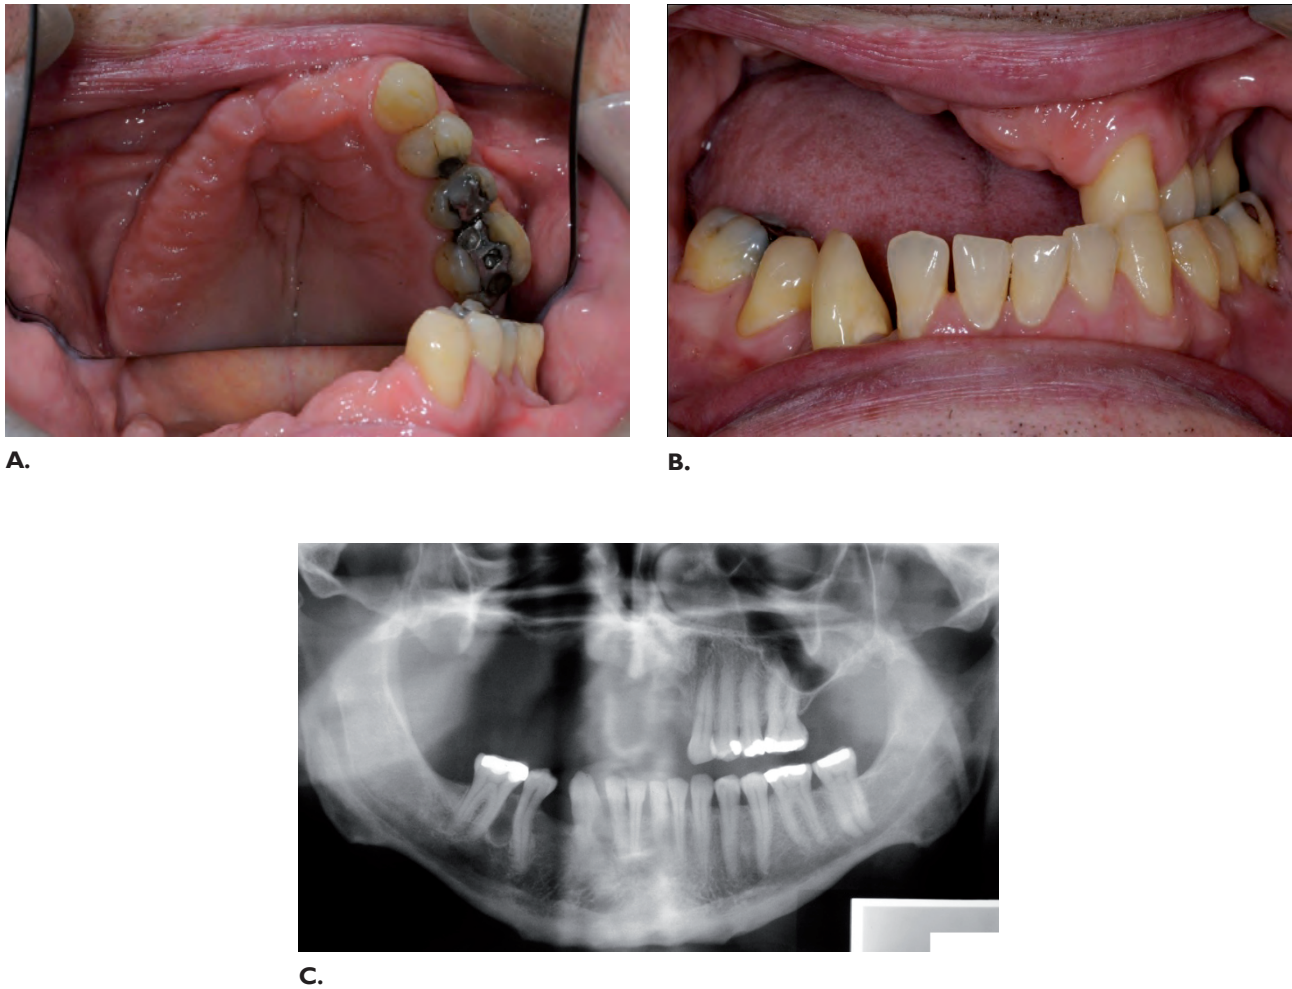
a) and b) Intraoral views showing pattern of tooth loss and associated loss of alveolar height and reduced sulcus depth. c) Radiograph showing lack of alveolar bone upper right maxilla and recurrent OKC between the LR5 and LR6, this was treated with local excision and curettage.
